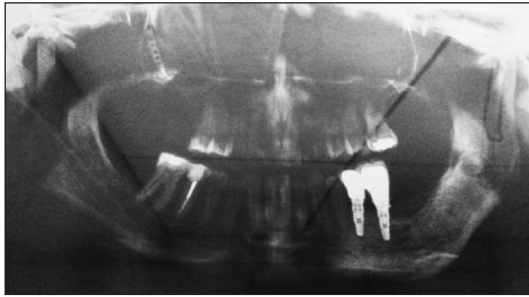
The radiographic view of the implants 2 years after the placement.
